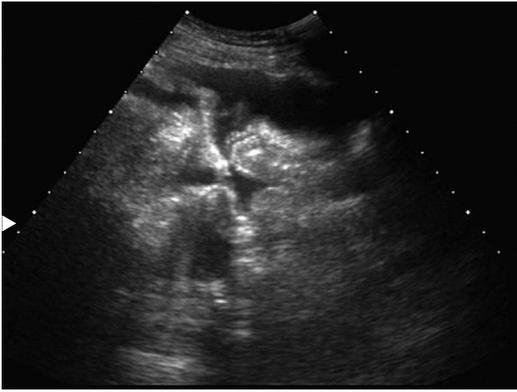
Ultrasonography of the abdomen revealed a moderate amount of ascites.
